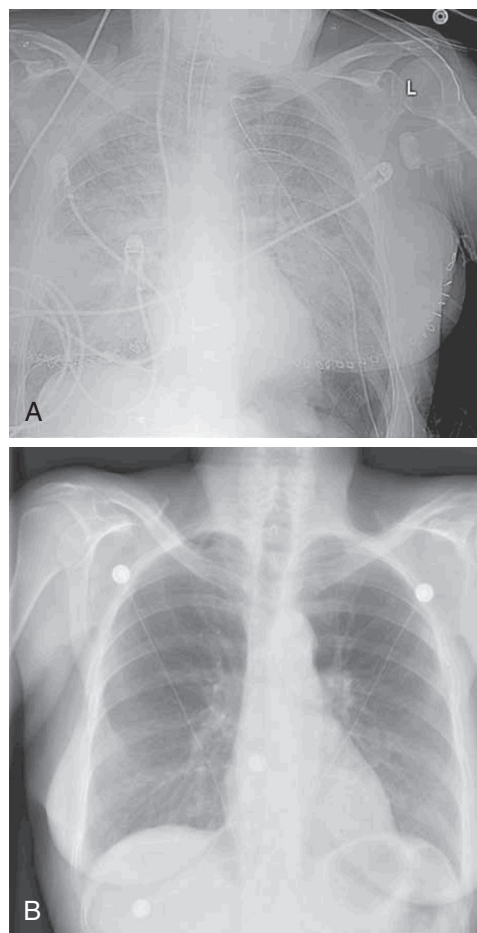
■ A, Chest radiograph showing diffuse consolidation typical of ischemic reperfusion injury. The right lung was implanted first, which explains the increased injury appreciated on this side. B, Radiograph of the same patient after complete recovery.
